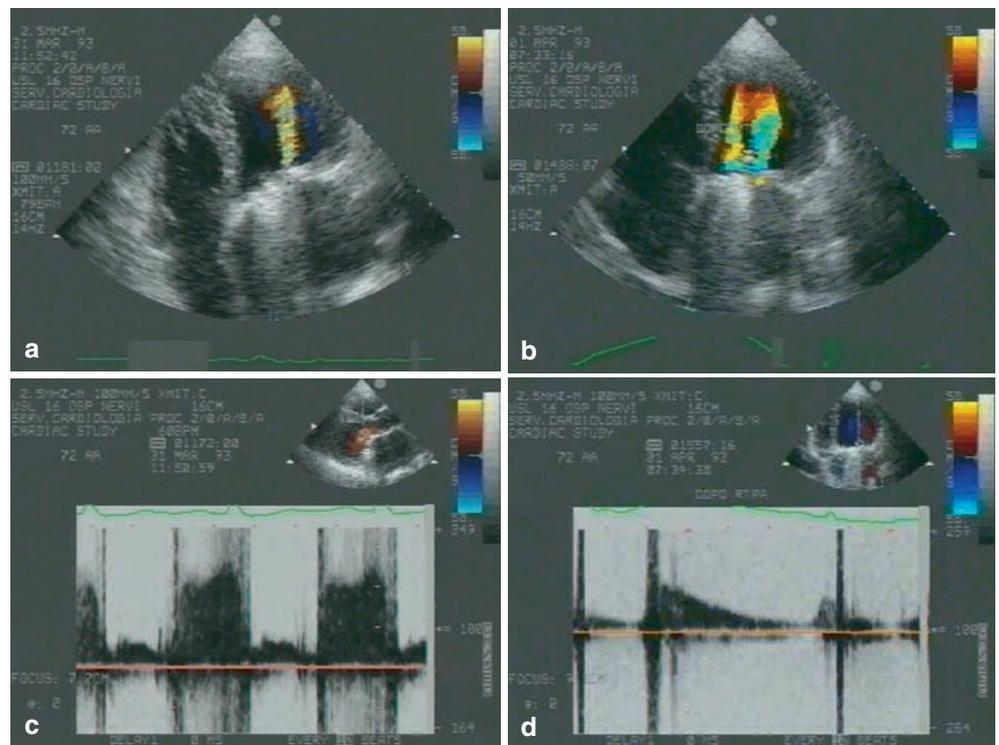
Single-tilting-disc valve thrombosis. Colour Doppler echocardiography at presentation (a) shows the absence of the central minor jet and increase in the velocity at CW spectral Doppler of the lateral major jet (c). After i.v. thrombolysis, the reappearance of the normal colour Doppler pattern of the anterograde flow (b) and a significant decrease in the anterograde flow velocity at CW spectral Doppler (d) were observed
